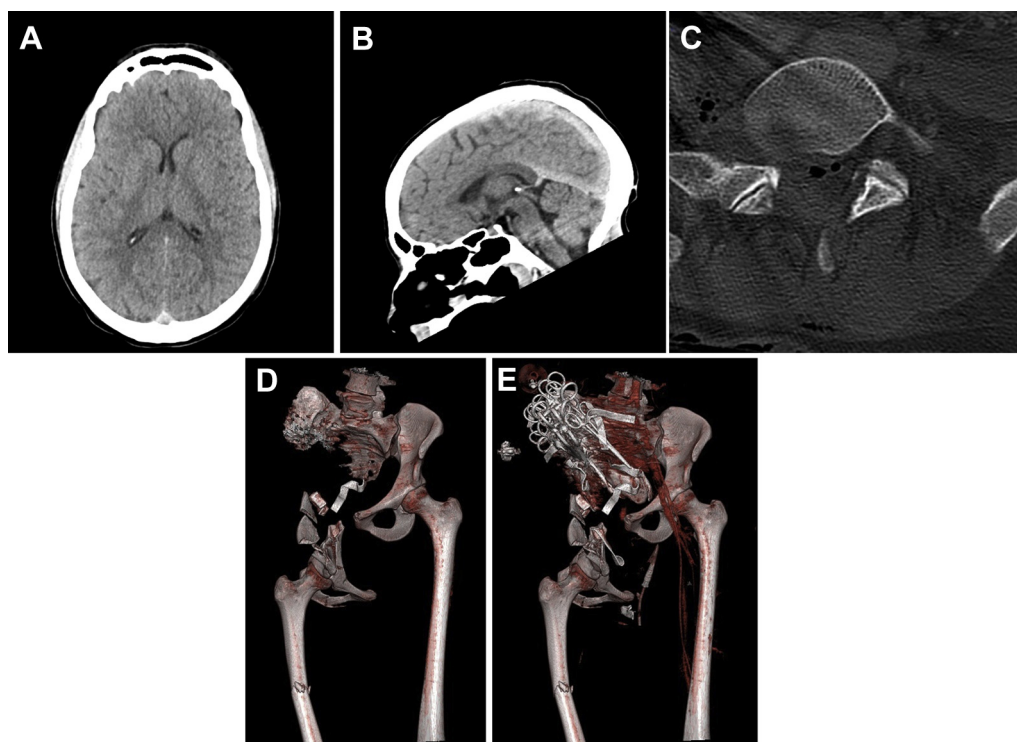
The initial computed tomography scan. (A) Head axial, (B) head sagittal MPR, (C) spine axial with intrathecal air, and (D and E) bone reconstruction showing a Grade 3 open pelvic fracture on the right side. MPR, multiplanar reconstruction.
